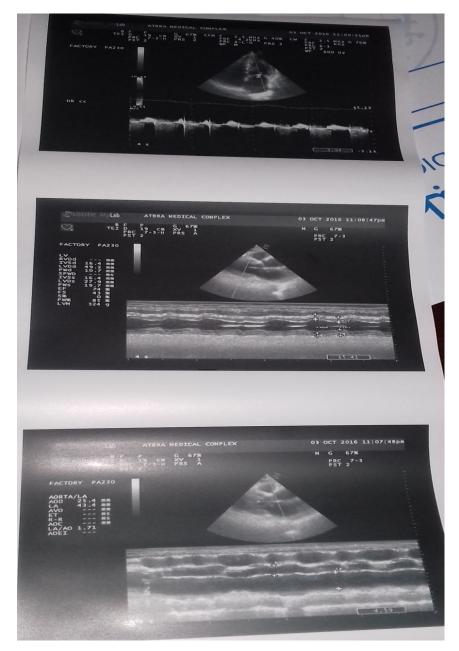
Image NO (7) 74 years old male LAX and apical 4 chambers view showing dilated LA and mild MR.
